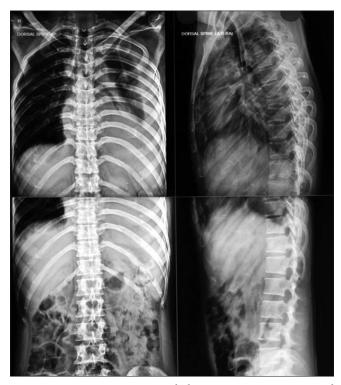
Preoperative X-ray whole spine anteroposterior and lateral view showing osteolytic lesions in D8 and L3 vertebral bodies with erosion and collapse of D8 vertebra.
